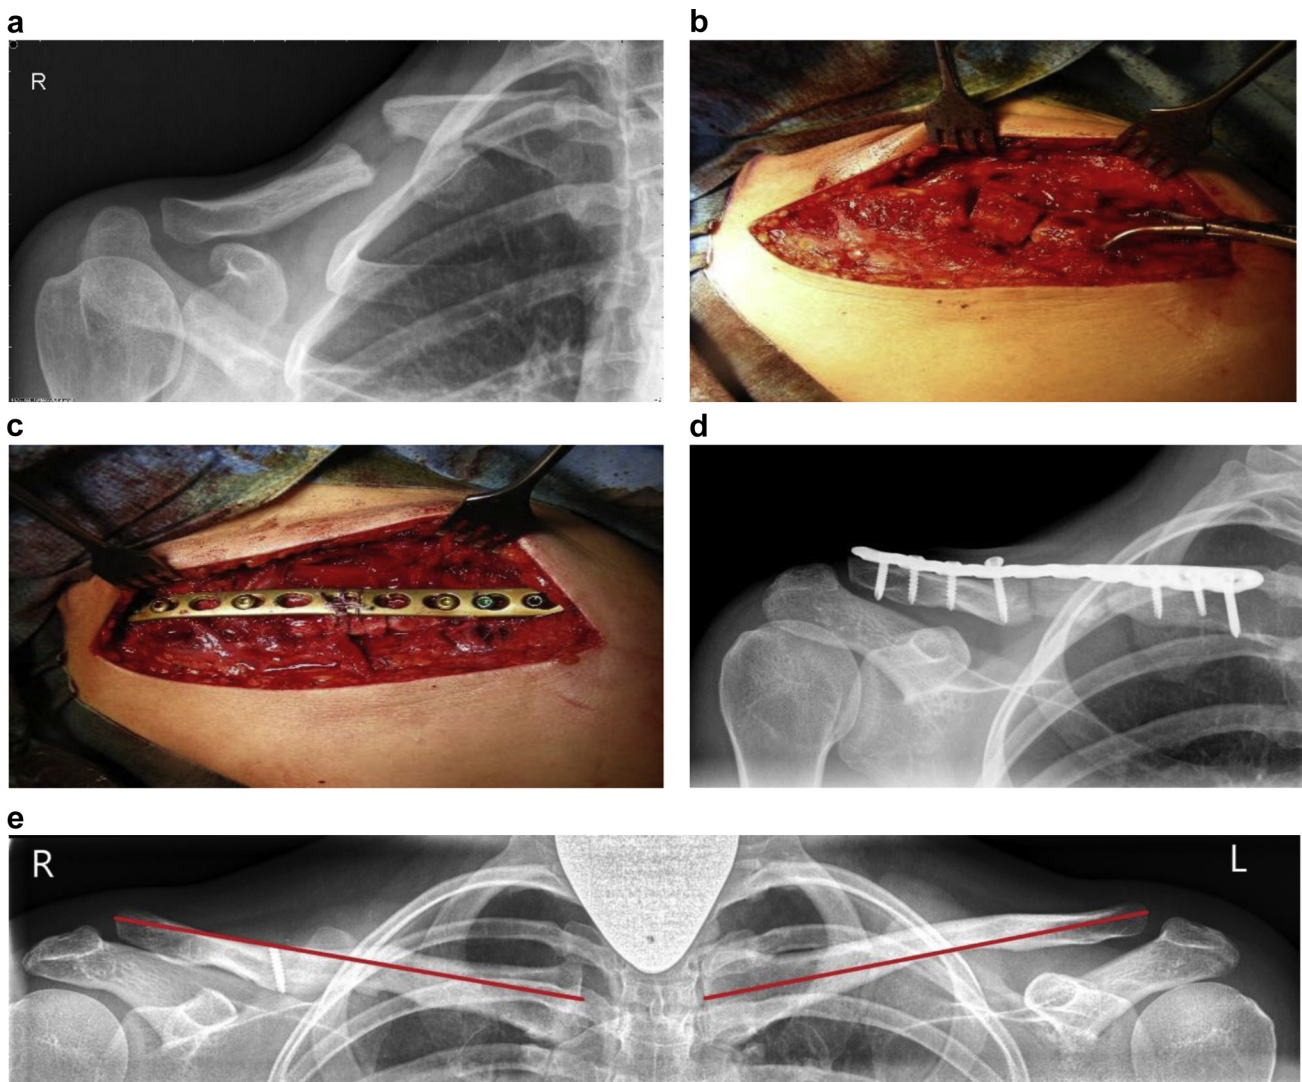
(a) Anteroposterior radiograph of a 23-year-old female patient with a right-sided midshaft clavicular fracture nonunion 15 months after undergoing conservative treatment. Surgical treatment was performed with a 2-cm iliac bone graft (b) and combined with single plating (c, d). Plate removal was performed at 3.8 years. (e) A panoramic radiograph taken 10.8 years after surgery shows complete bone union. The landmarks—as defined by Smekal et al²⁵—at the clavicular joints were used to measure the clavicular length difference between sides; the — indicate the linear distance between the acromioclavicular and sternoclavicular joints. R, right; L, left.
